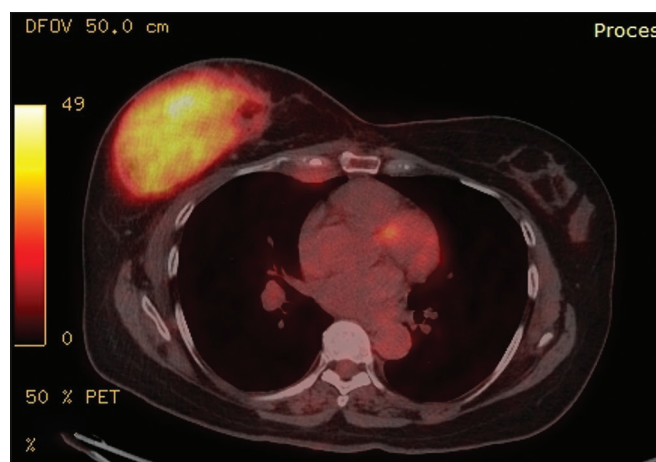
PET/CT image showing increased FDG uptake in the mass in the right breast with SUV_{max} of 9.4
